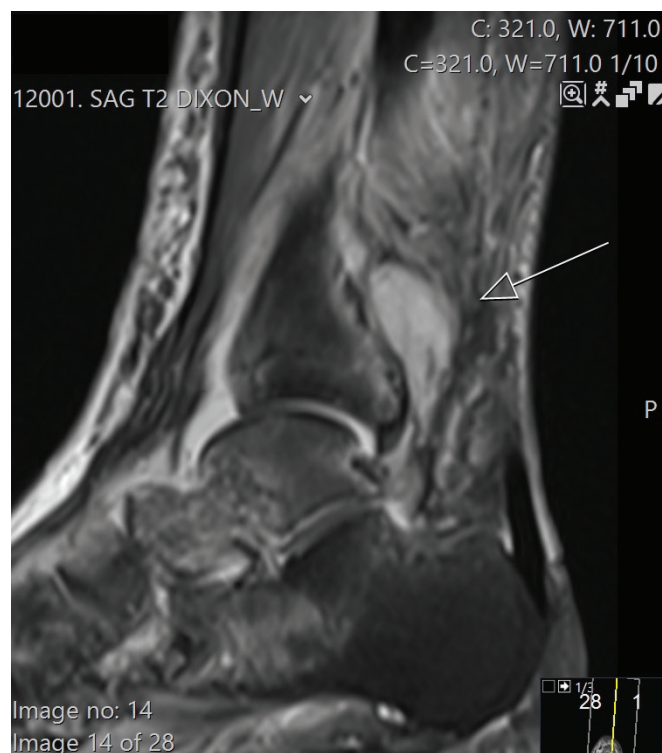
Magnetic resonance imaging of the ankle: sagittal view with T₂-weighting showing findings suggestive of abscess with high signal (arrow) posterior to the distal tibia.
